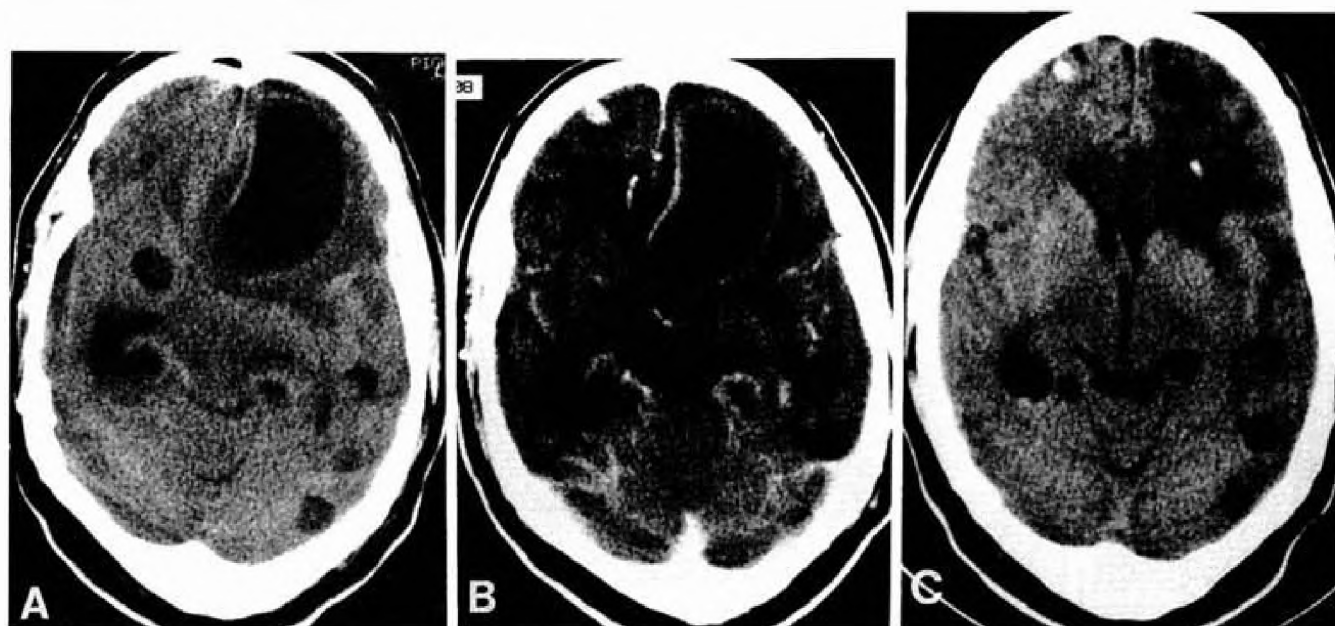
A 43-year-old man with decerebrate posturing and a history of progressive headache and untreated seizures. An unenhanced CT scan (A) reveals a large left frontal cyst with marked mass effect. After administration of intravenous contrast (B), a thin enhancing cyst wall is evident, which suggests Stage 2 disease (dying cyst). Note the additional smaller asymptomatic cysts throughout the parenchyma. The meningeal enhancement indicates associated cysticerebral arachnoiditis. After stereotactic placement of a cyst catheter-reservoir, the cyst was progressively drained over a period of 1 week. A follow-up CT scan 2 weeks after admission (C) shows resolution of the large frontal cyst with the indwelling catheter. This patient was given praziquantel concurrently and had successful resolution of other intracranial cysts.
